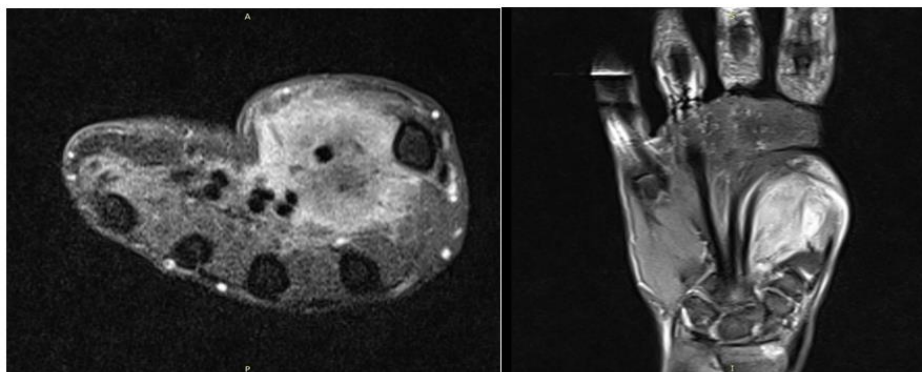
Axial and coronal section. MRI of right-hand swelling showed a small soft tissue lesion in the right thenar region circumferential involving flexor pollicis longus tendon along its course
